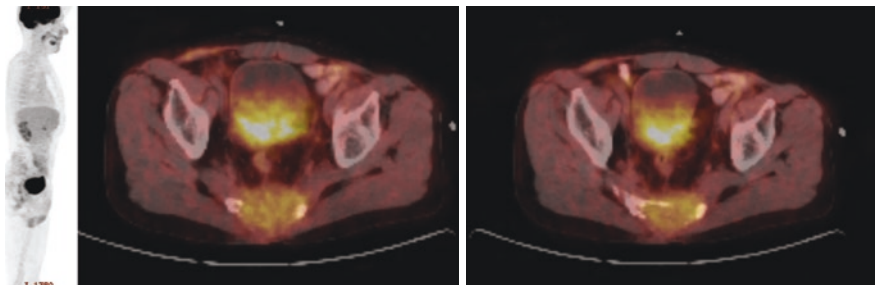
PET/CT images of sacral chordoma
